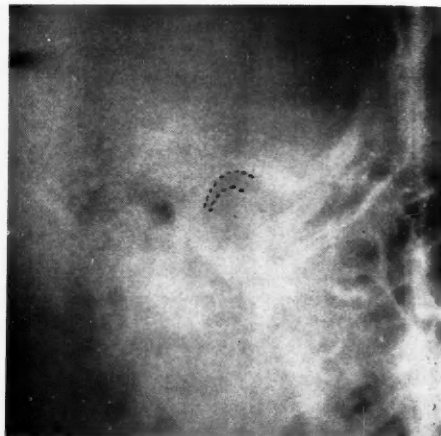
Radiograph of "reduced" joint space.
